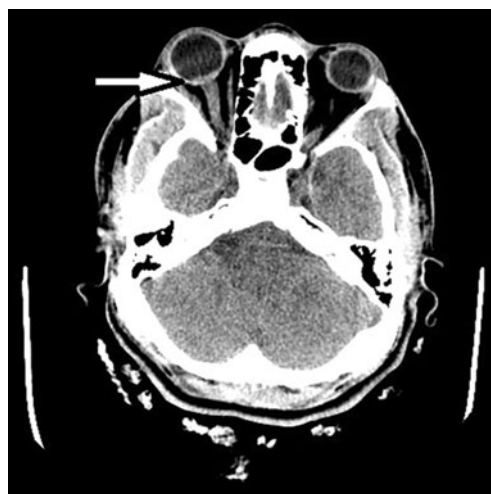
Axial noncontrast CT image demonstrates faint linear hyperdensity at the level of the posterior chamber of the right globe compatible with Terson hemorrhage dissecting in a subhyaloid fashion over the optic disk. Similar changes were seen in the left globe (not shown)
